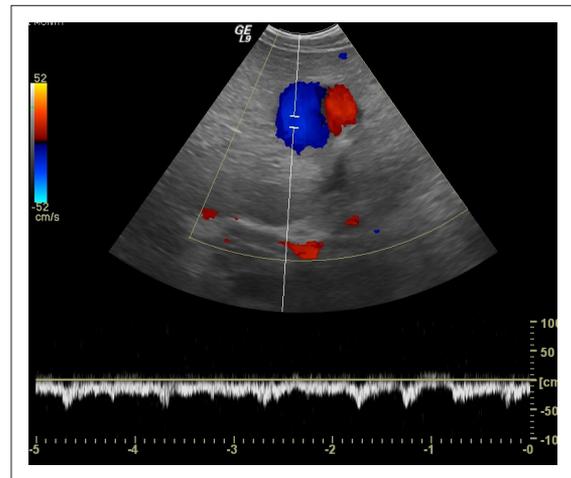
Doppler sonography of the liver. The spectral waveform of the portal vein showed mixed arterial and venous waveform, suggesting fistula between portal vein and hepatic artery.
